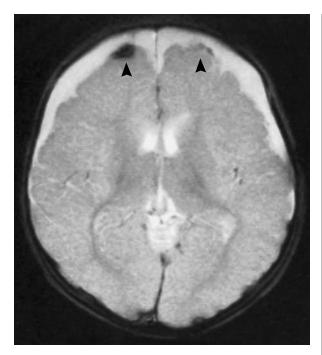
T₂-Weighted Axial Cranial MRI Scan in a Four-Month-Old Girl Reported to Have Fallen from a Low Height. Gradient-echo imaging was used with the technique of the fast low-angle shot (FLASH) to demonstrate blood products. Areas of acute hemorrhage on both frontal cortical surfaces can be seen (arrowheads), along with proteinaceous extraaxial collections. This infant also had multiple rib fractures.
